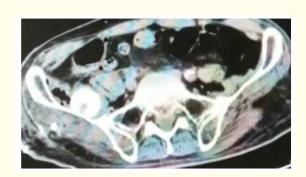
A post-operative 3-month CT scan showing no change in position of trial femoral head.
